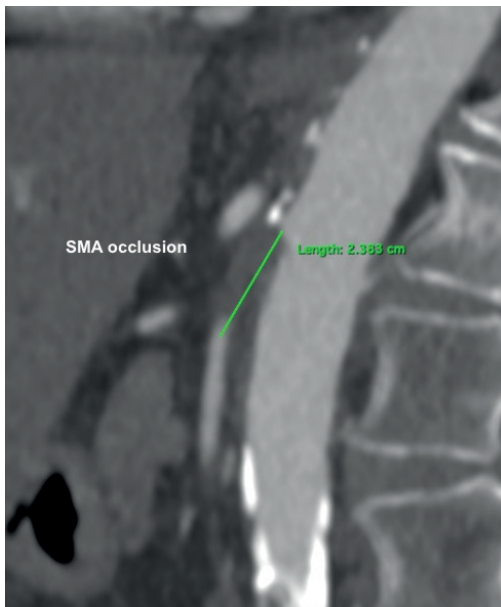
CT scan showing SMA occlusion.
